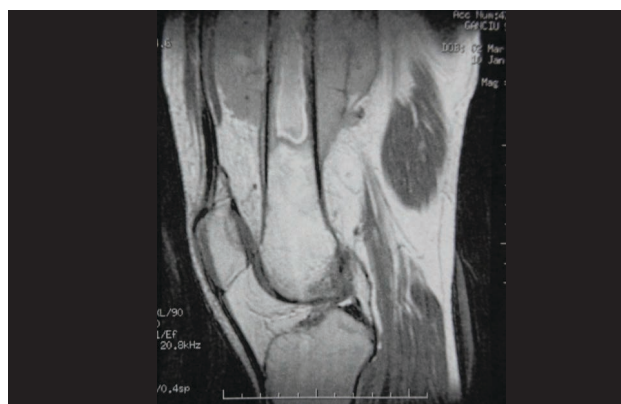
The MRI scan describes the space occupying process on the distal third of the femur (on the left). 3-D reconstruction of MRI shows cortical lesions, and periosteal reaction on the level of the tumor (on the right)
